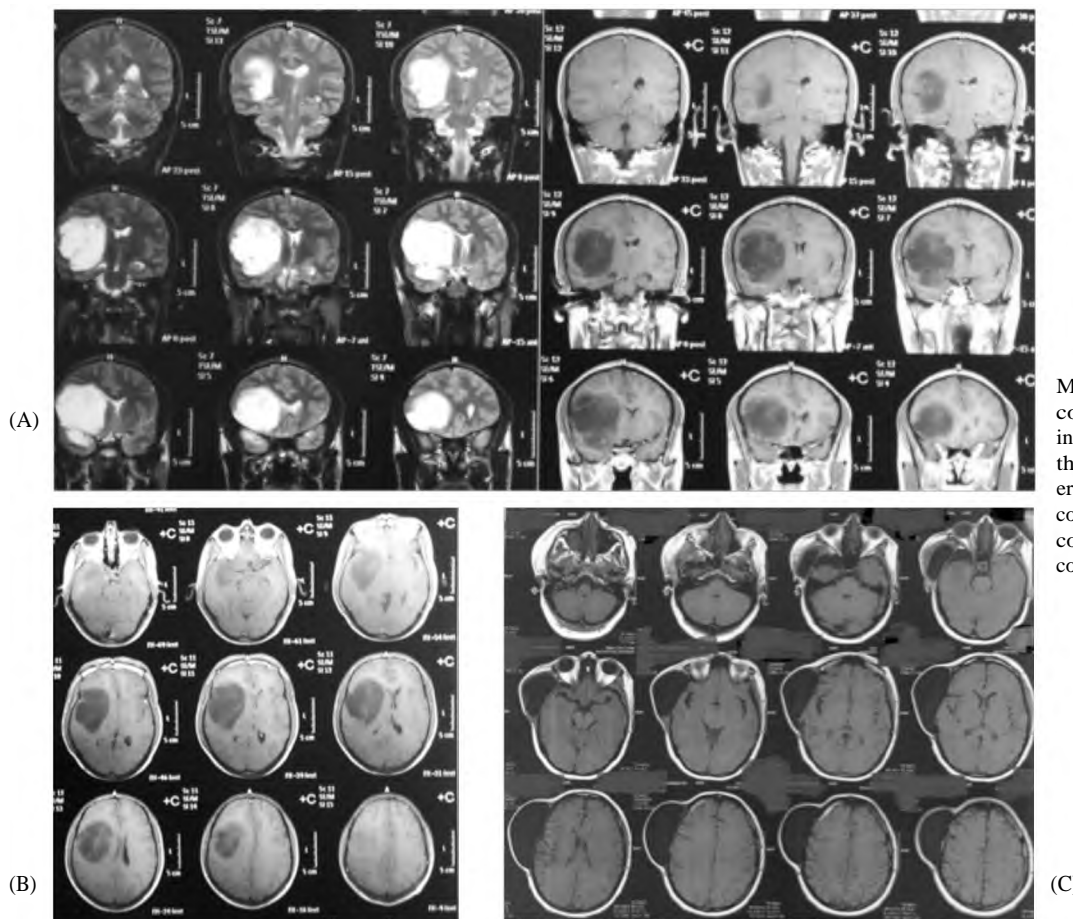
Preoperative MRI brain (A,B,C) with contrast showing large insular glioma occupying the 4 zones and postoperative MRI (D) showing complete resection with a collection that managed conservatively.
